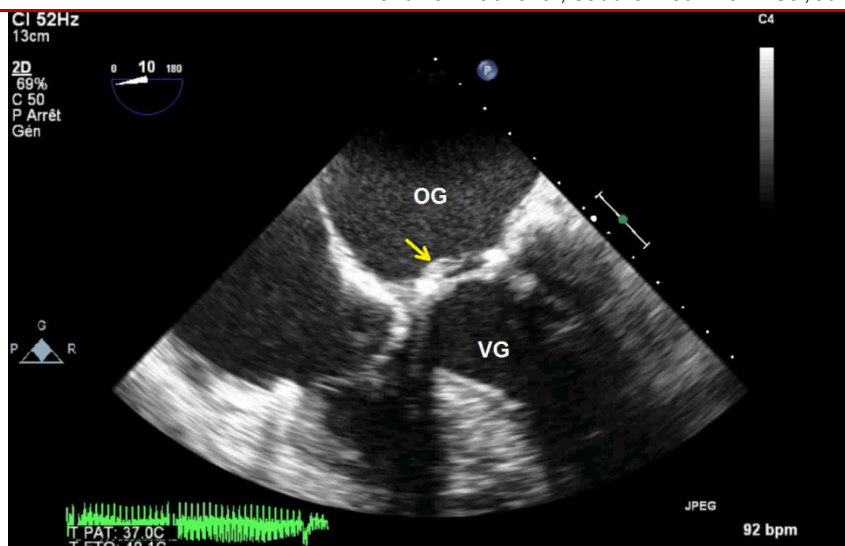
Transesophageal echocardiography showing vegetation at the expense of the ring and the large mitral valve
